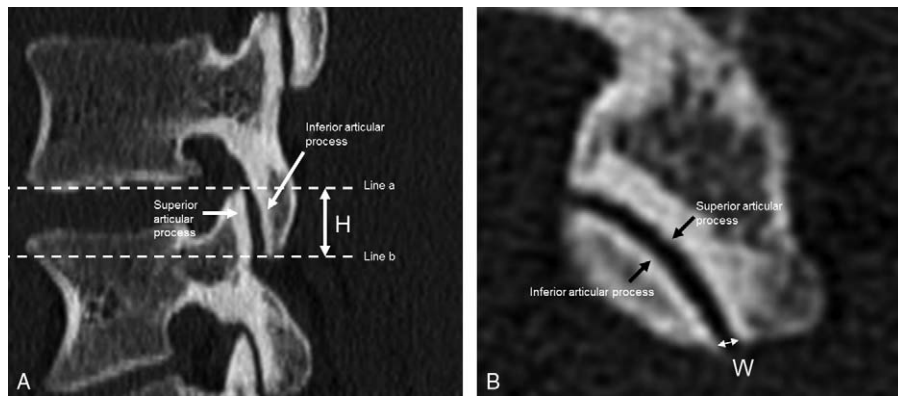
CT image of facet joints. (A) Facet joint of the CT imaging in the parasagittal plane. Parameter of H of the facet joint was defined as the greatest dimension from the cranial (line a) to the caudal point (line b) between the inferior and superior articular processes. (B) Facet joint of CT imaging in the transverse plan. W of the facet joint was the greatest dimension perpendicular to the posterior portions of the joint surface.
